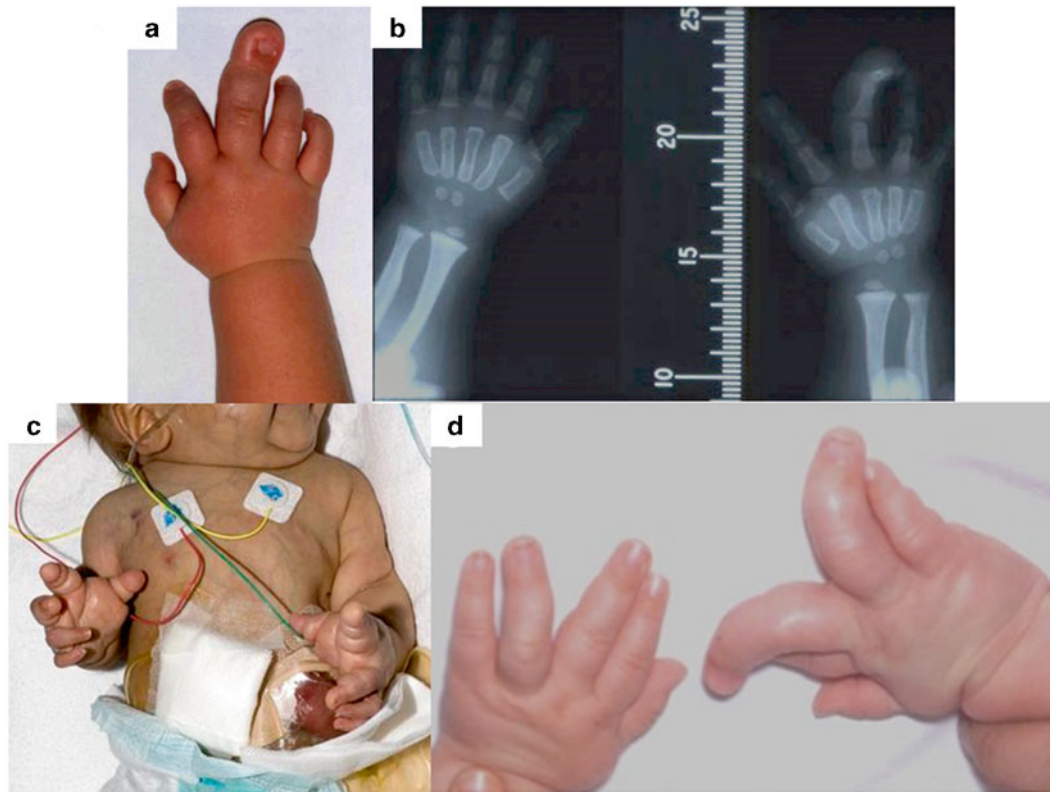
The multiple variations of upper limb macroductyly: (a) Progressive unilateral macroductyly of the right middle finger. (b) Radiograph of the hands with the superimposition of a measure to allow
